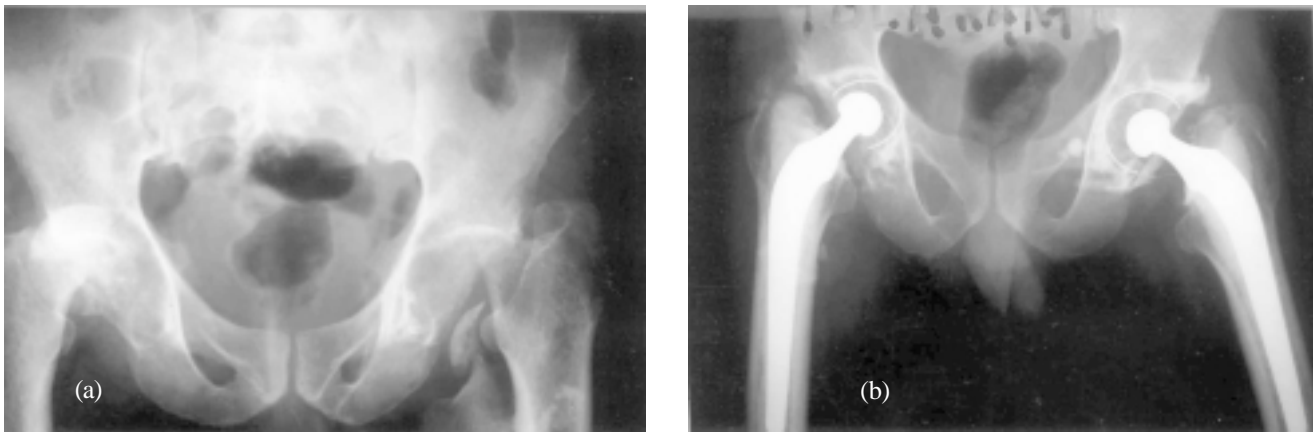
(a) Radiograph showing bilateral fracture of neck of femur with bilateral dislocation of hip. (b) Follow-up radiograph 6 years after bilateral hip arthroplasty.
